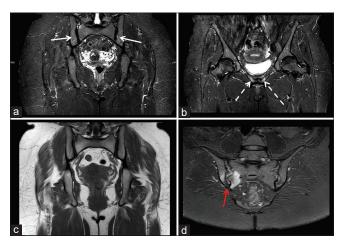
Magnetic resonance imaging (MRI) was performed on a young female patient who presented with heavy menstrual bleeding with lower pelvic and back pain. Initial MRI imaging of the pelvis was performed (coronal short inversion time inversionrecovery [a-b] and [c] T1-weighted sequences) which demonstrated no abnormality in both sacroiliac joints (SIJs) (solid white arrow). Periarticular bone marrow edema in both pubic symphyses (dashed white arrow) was noted in keeping with a diagnosis osteitis pubis. No gynecological cause for the pain was identified. It was noted that the patient's pain occurred in flares and related to catamenial inflammation. A subsequent MRI of the SIJs (d) performed 6 months later and demonstrated the manifestations of axial SpA (red arrow) and the patient was later fully diagnosed with psoriatic arthropathy.
